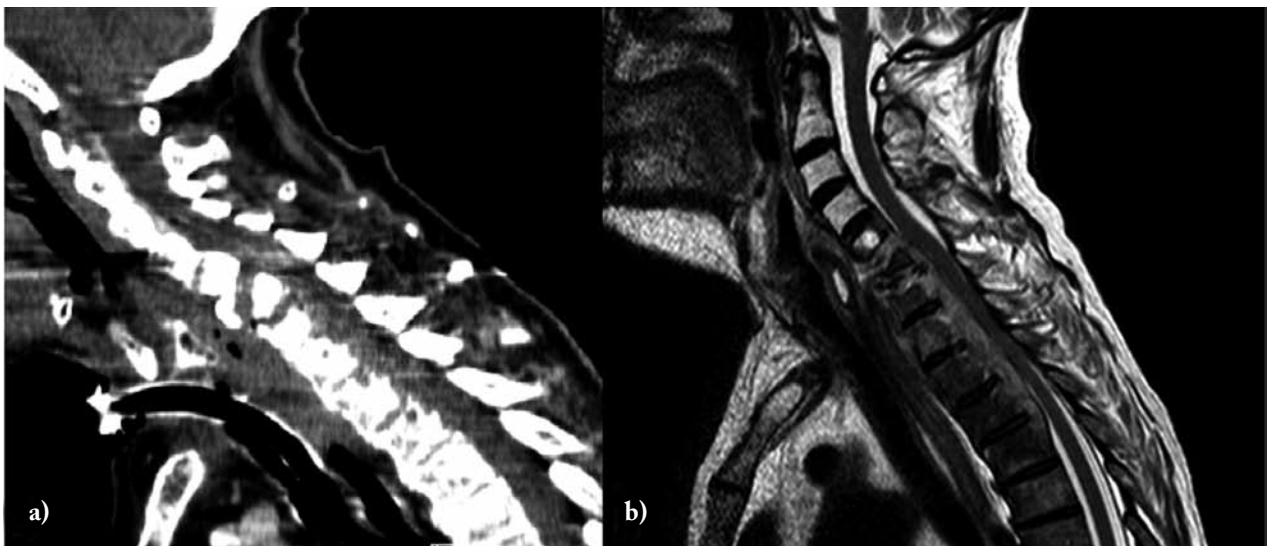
Sagittal CT (a) and T2-weighted MR imaging (b) showing a large, irregular and contrast enhanced mass wrapping the vertebral bodies from C5 to T4 with involvement of the intervening disks; diffuse demineralization of vertebral bodies involved; osteolytic lesion of C5; collapse with cuneiform deformation of C6; gas bubbles in the prevertebral space and anterior epidural space; slight compression of the dural sac at the level of T1
